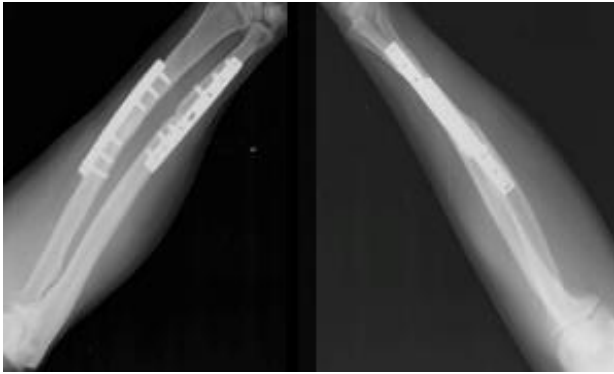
3 Months post-operative x-ray.
